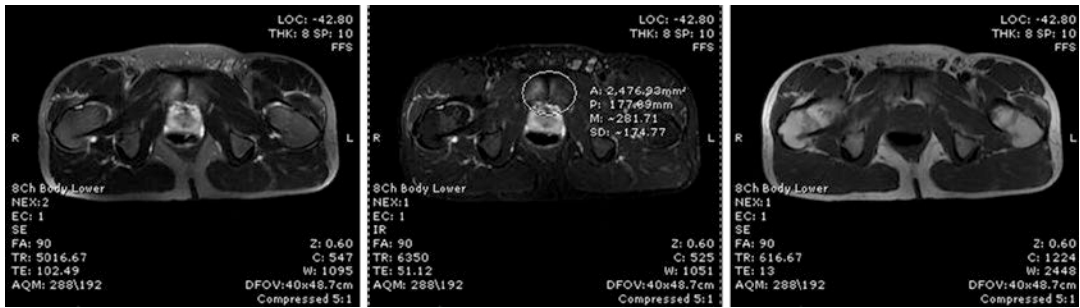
MRI for chronic groin pain in a runner revealing mild degenerative changes of the pubic symphysis with parasymphyseal bone marrow edema suggestions stress/reactive edema due to repetitive stress
